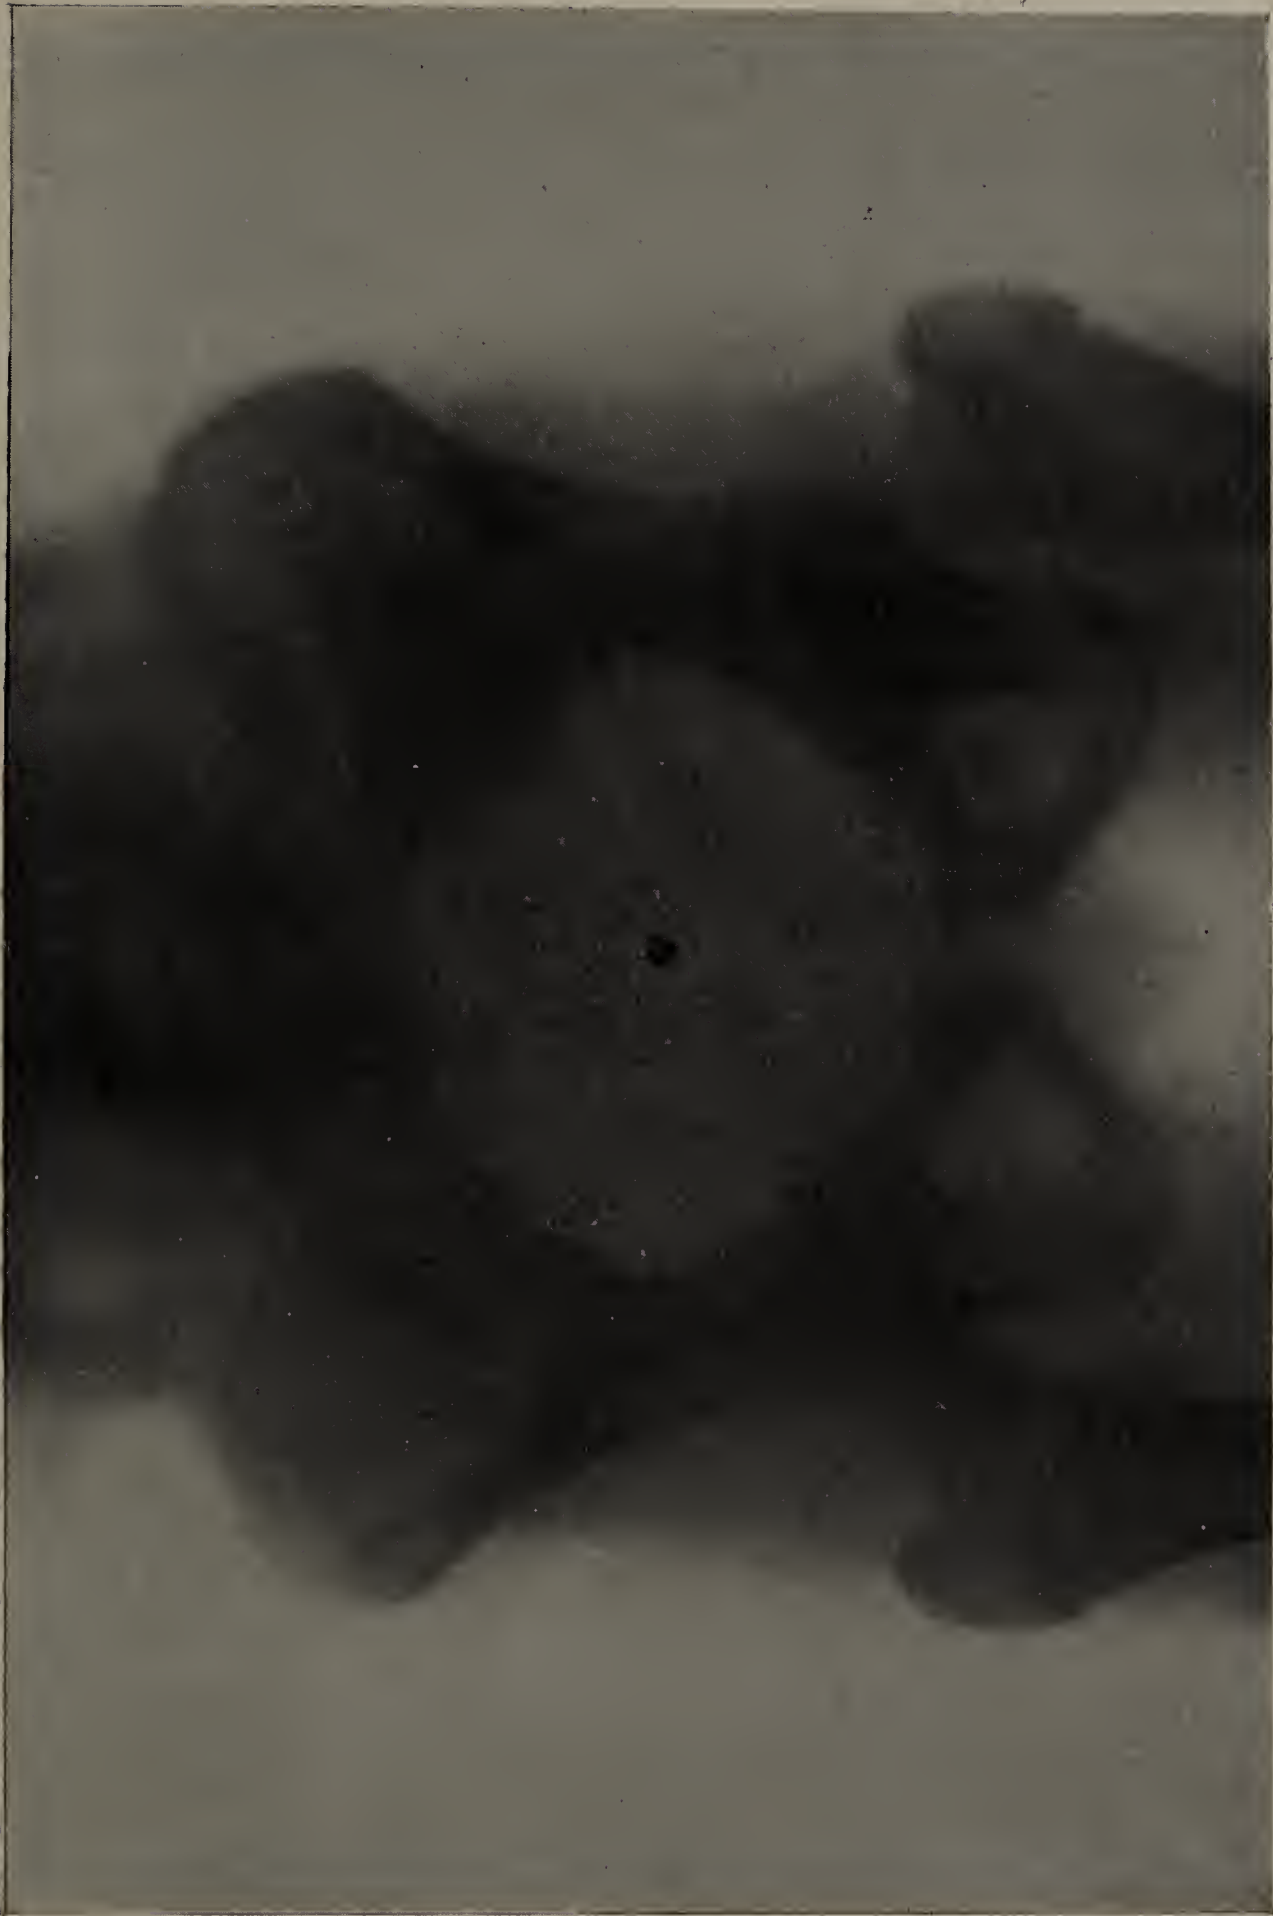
The same pelvis as taken in Fig. 214, but radiographed at one exposure; consequent exaggeration in diameter of brim (1.5 centimetres) due to the position of the tube with regard to the brim and the plate.
